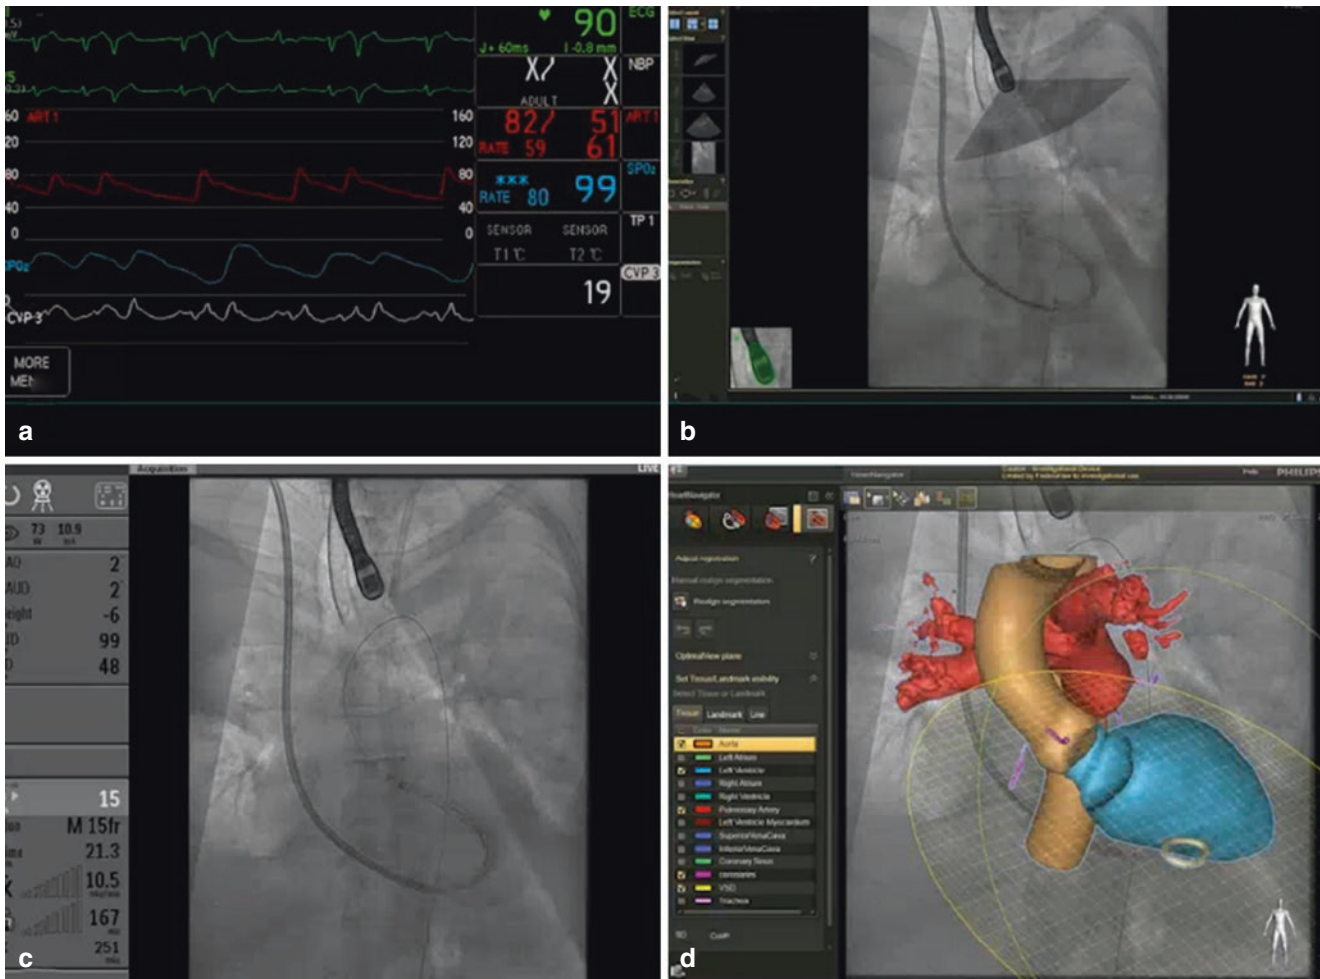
Display of hemodynamic and integrated imaging during procedures. Operators can have comprehensive information displayed on the screen. (a) Live hemodynamic data is displayed on the upper left. (b) Echo-fluoroscopy fusion is shown where relevant information from transesophageal echocardiography (TEE) are fused to fluoroscopy. (c)
